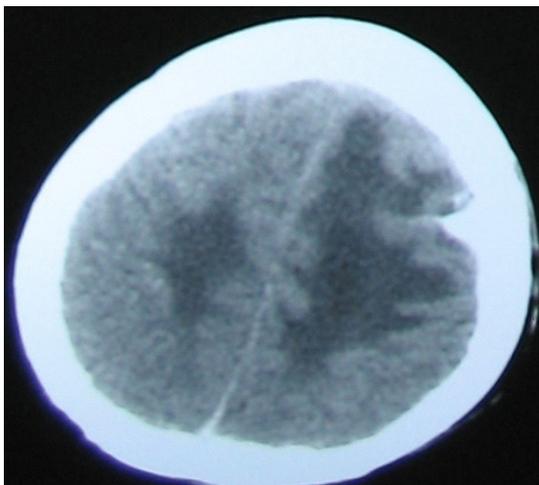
Non contrast enhanced CT scan head showing venous infarct over bilateral fronto- parietal lobes with overlying depressed bone fracture
